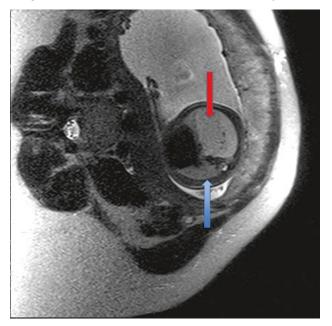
MRI of maternal abdomen with transverse section of fetal lungs in the uterus. Upper arrow points to a large left lung mass. Lower arrow points to a markedly diminished, normally structured right lung
